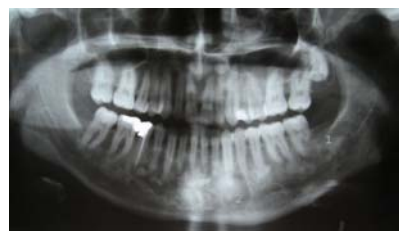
Panoramic radiograph taken at the postoperative 1st year showing increased radiopaque areas due to the maturation of the lesions.
